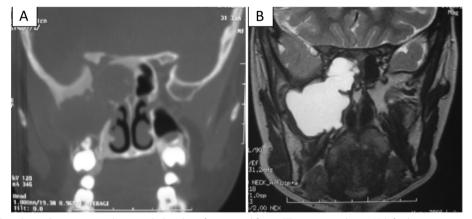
Case 1. Right sphenoid sinus mucocele expanded to the infratemporal fossa. CT scan coronal view (A left) showing a 6-cm liquid area in the right sphenoid sinus and infratemporal fossa with skull base damage and several sites of hypertrophic bone with a frosted-glass aspect characteristic of fibrous dysplasia. MRI coronal view (B right) confirmed the inflammatory nature of the effusion (hypersignal on T2-weighted image), ruled out a diagnosis of meningocele, and confirmed the diagnosis of mucocele
